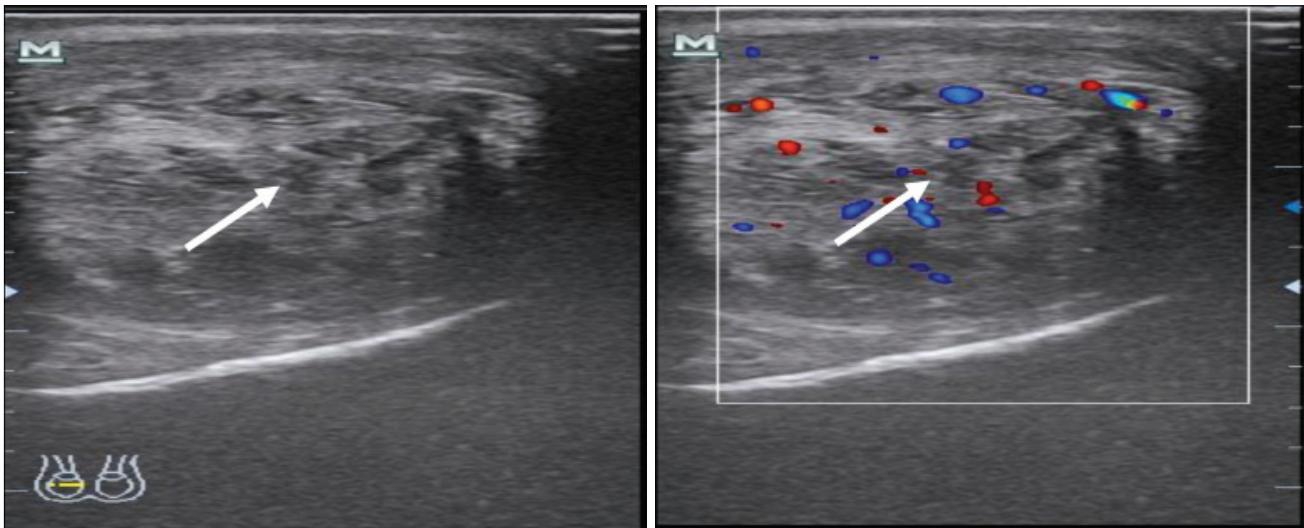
Ultrasound of the right testis showing a well-defined heterogeneous mass with internal vascularity in the right scrotum (white arrows).
